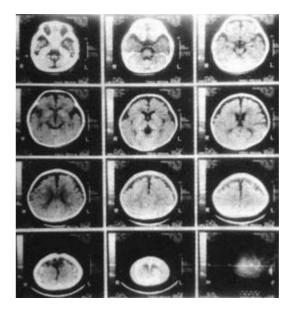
X-ray computerized tomographic scan of a 10 month old baby showing mild cortical atrophy and enlarged subdural space in the both frontal labes.
